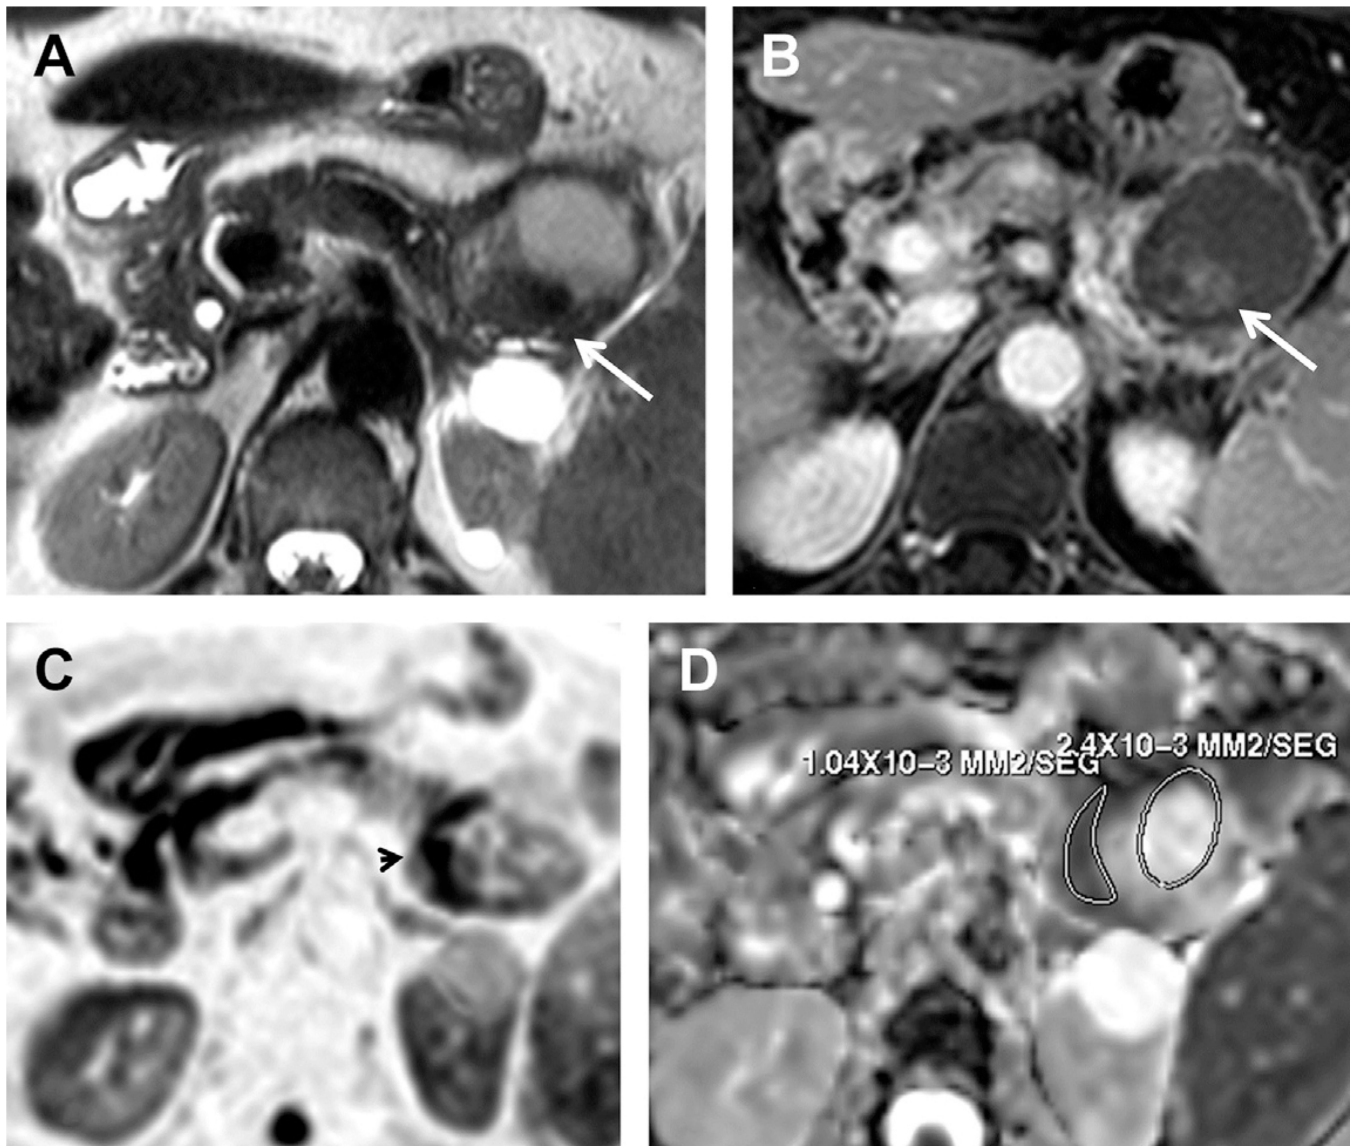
Malignant MCN. (A, B) Axial TSE T2-weighted image and (B) axial postcontrast THRIVE during the venous phase show a complex cystic lesion with solid peripheral neoplastic component that shows enhancement and a mural nodule (*arrows*). (C, D) Diffusion-weighted image (*b*: 800 mm²/s) with inverted gray-scale and corresponding ADC map demonstrate restriction of water motion in the solid mural thickening (*arrowhead*), with ADC value of 1.04×10^{-3} mm²/s. ADC of the cystic component is 2.4×10^{-3} mm²/s (ROIs).
